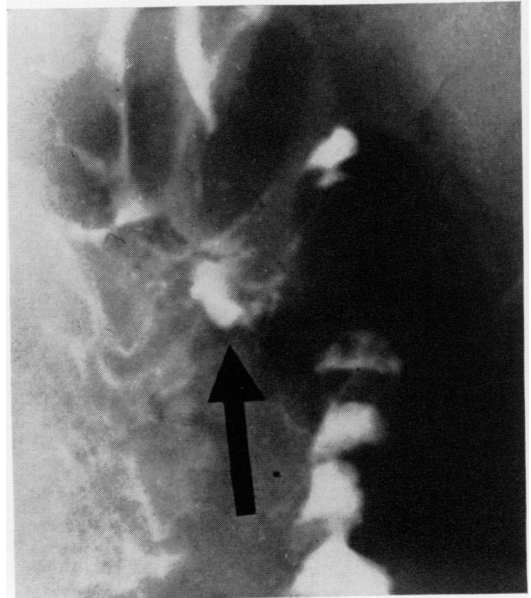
Photograph of x-ray demonstrating the initial jejunal ulcer.
